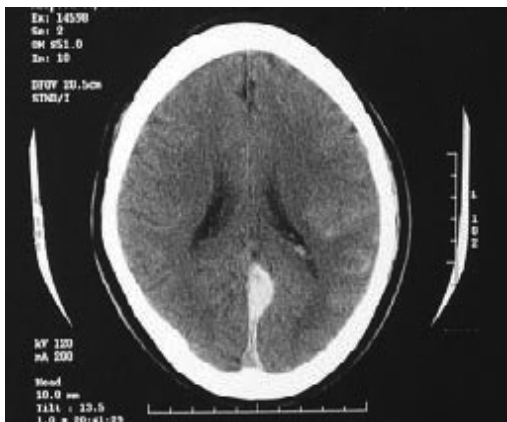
CT showing ISDH involving posterior third of falx
